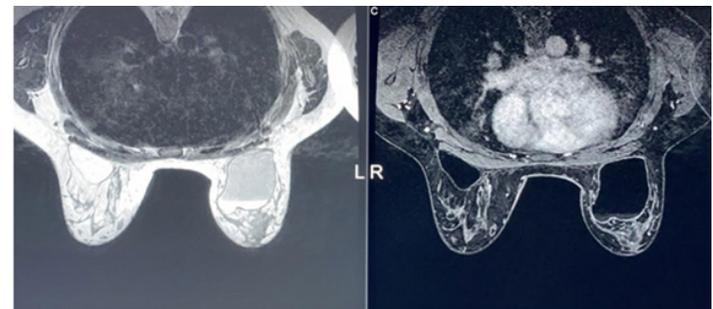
MRI-T2 WI with Fat suppressed images showing loss of signal on fat suppression. And peripheral contrast enhancement—impressive of fat necrosis
